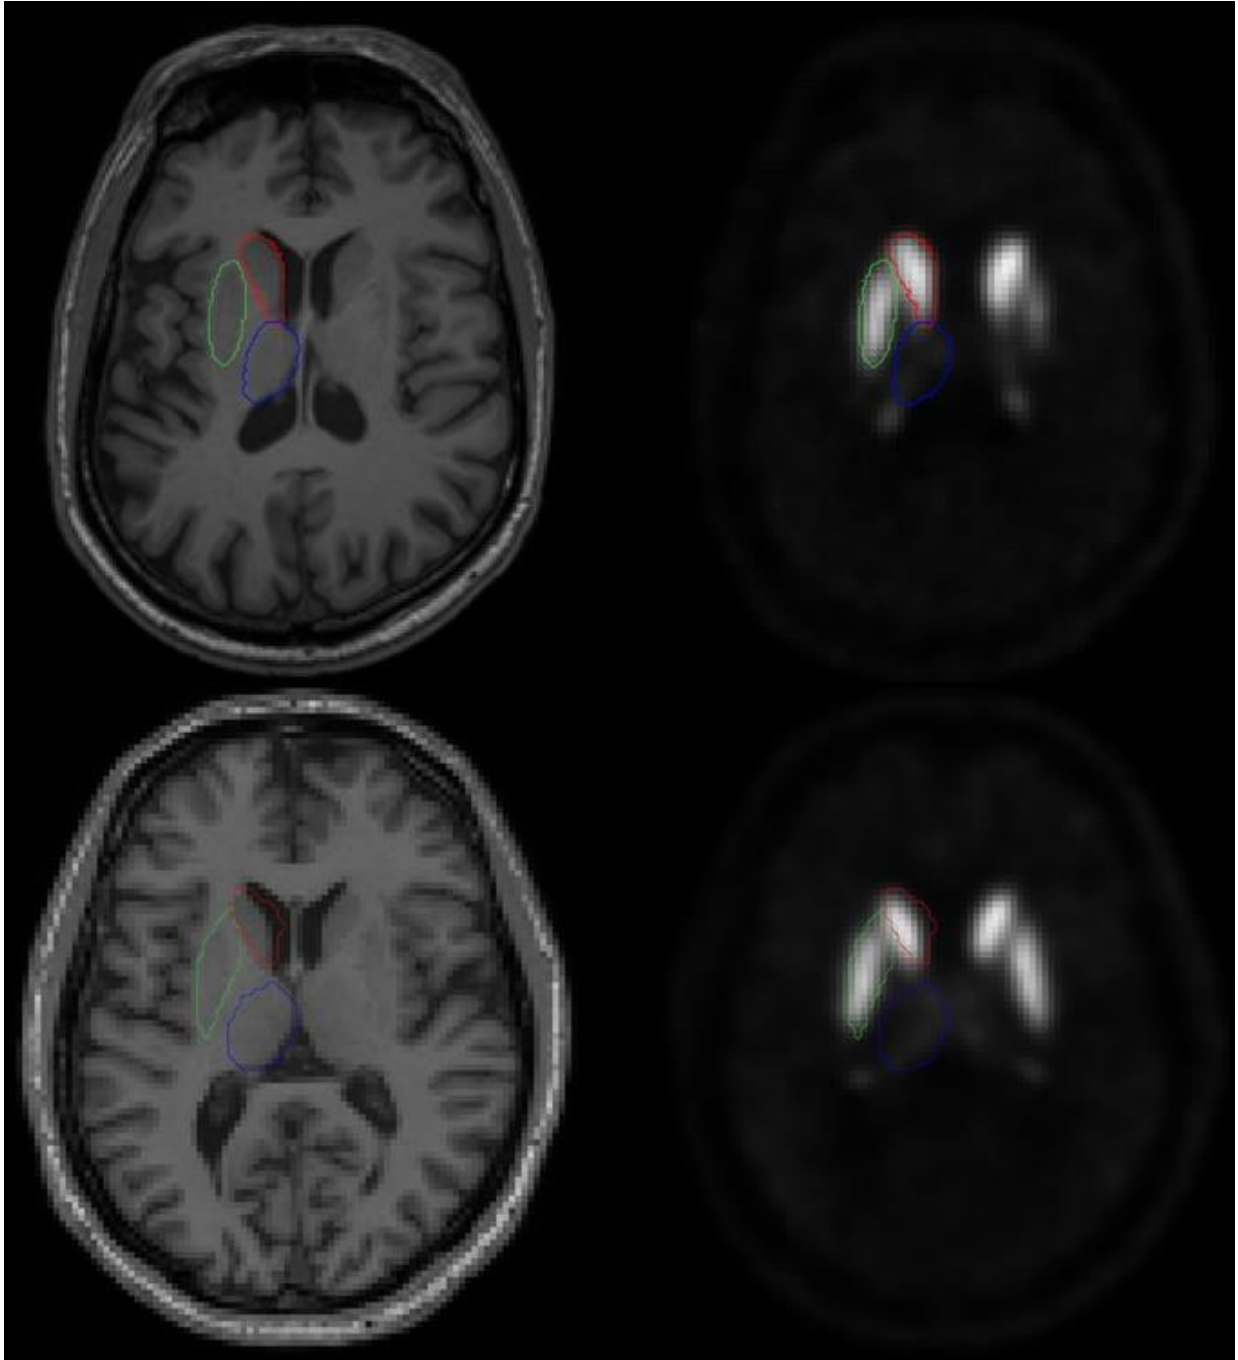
Example images of ROI fits. Top left shows an example of an axial slice of a subject's MRI image in neurologic convention, in conjunction with the subject's FSL FIRST segmentation of the left putamen (green), caudate (red) and thalamus (blue). Top right, the same subject's PET (image block 2, image 2) with the same FSL FIRST segmentation. Bottom left shows the same subject's normalized MRI in conjunction with the AAL ROIs for the left putamen (green), caudate (red) and thalamus (blue). Bottom right shows the same subject's normalized PET image (image block 2, image 2) with the same AAL ROIs.
